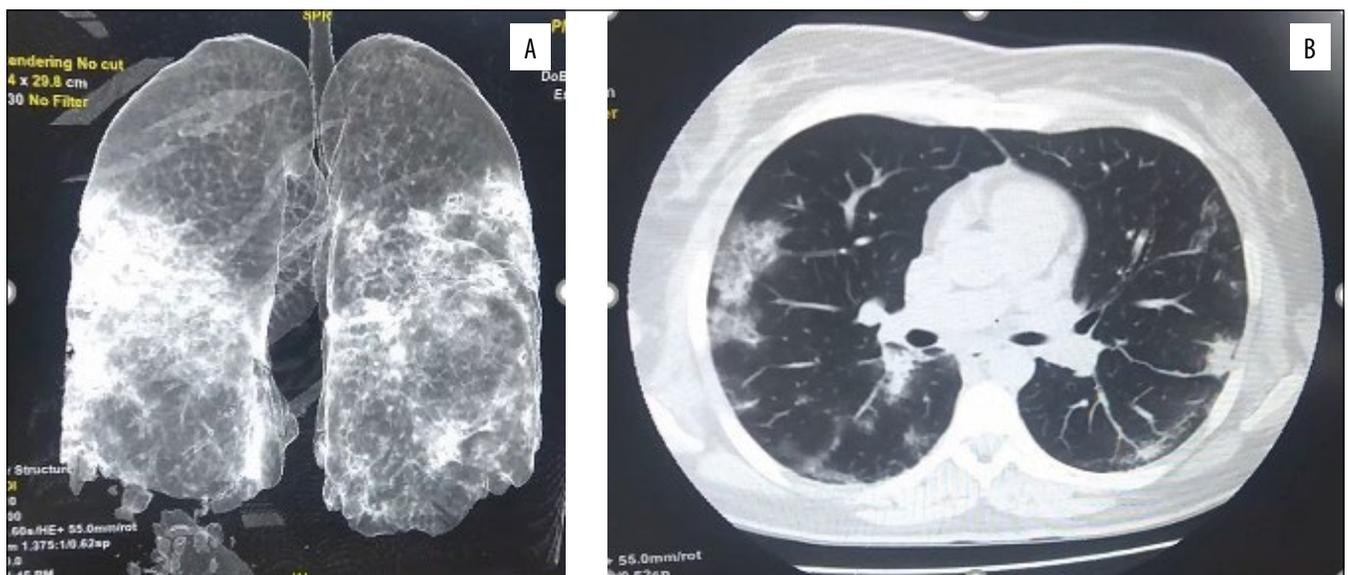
Lung CT scan of the patient N. (day 18 of illness), demonstrating the signs of viral bilateral pneumonia, with involvement of 25-50% of the lung parenchyma (stage 2 [12]). (A) 3D reconstruction; (B) axial plane.
